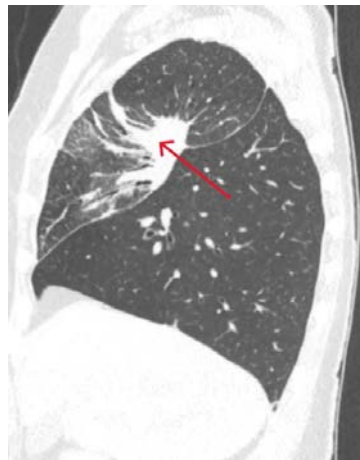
Sagittal plane of the chest, computed tomography scan: the arrow indicates a tumor lesion in the upper right lobe with infiltration and compression of the main bronchus.
